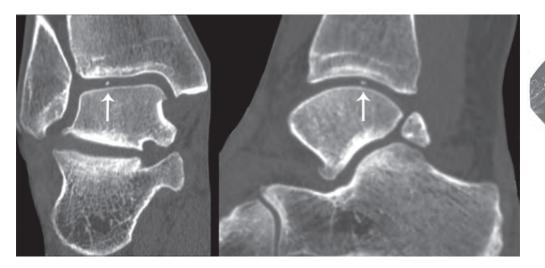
CT scan of a right ankle that shows a loose body, which is situated in the talar cartilage (arrow). Coronal (left) and sagittal (right) reconstructions are shown.
